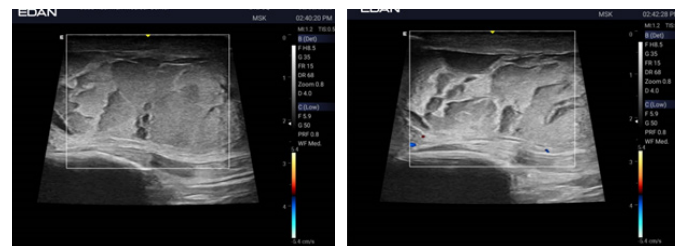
Long-axis Doppler ultrasound of the anterior knee joint presented a well-defined cystic lesion, exhibiting internal lobulations and a turbid collection. No internal vascularity or solid components were identified.
